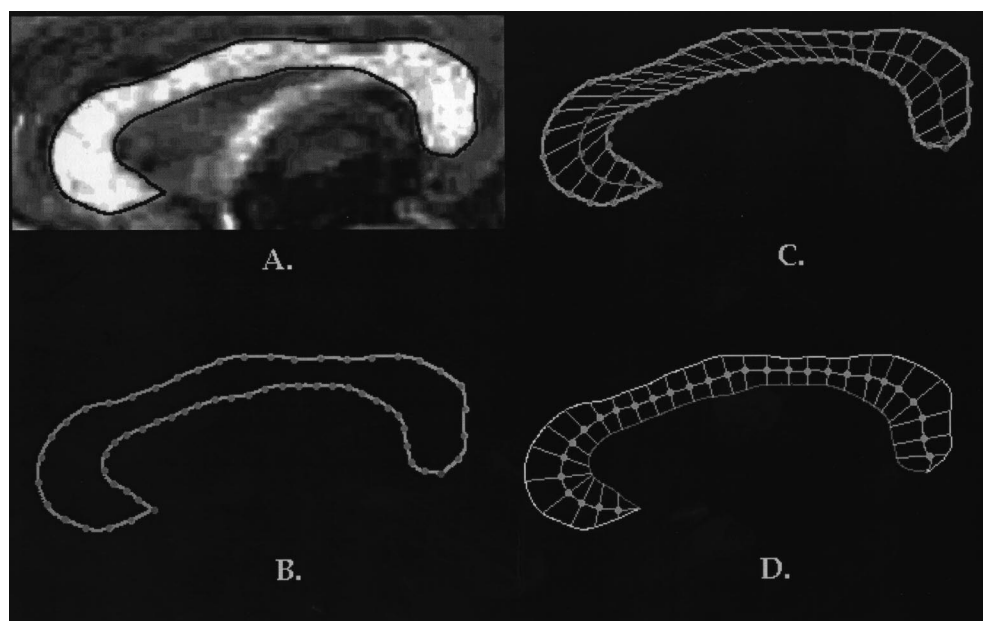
Method of dividing corpus callosum. (A) Corpus callosum traced on sagittal MRI section. (B) Corpus callosum spline curve fitted and divided into 30 equal segments. (C) Lines drawn connecting each outline division. (D) Thirty areas based on perpendiculars to the midline.
